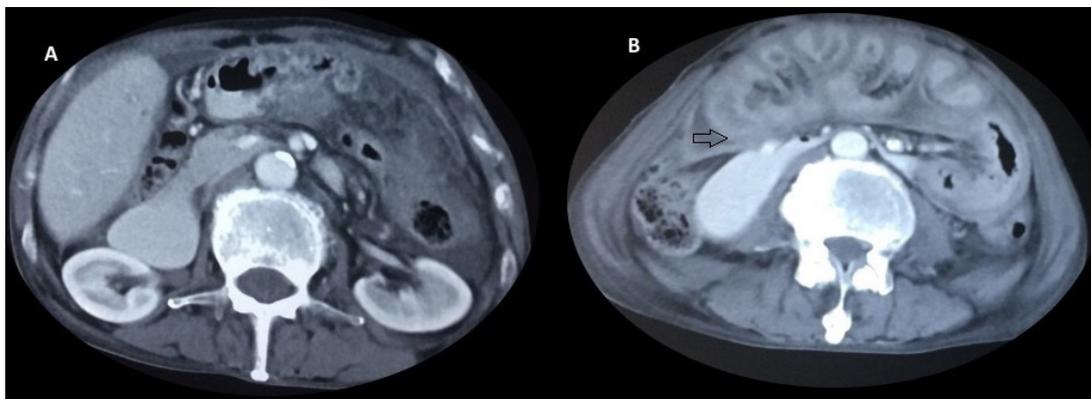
CT scan showing ascites (A) and clumped bowel loops encased by a membrane (B). The arrow indicates clumped bowel loops encased by a membrane (B). CT, computed tomography.
